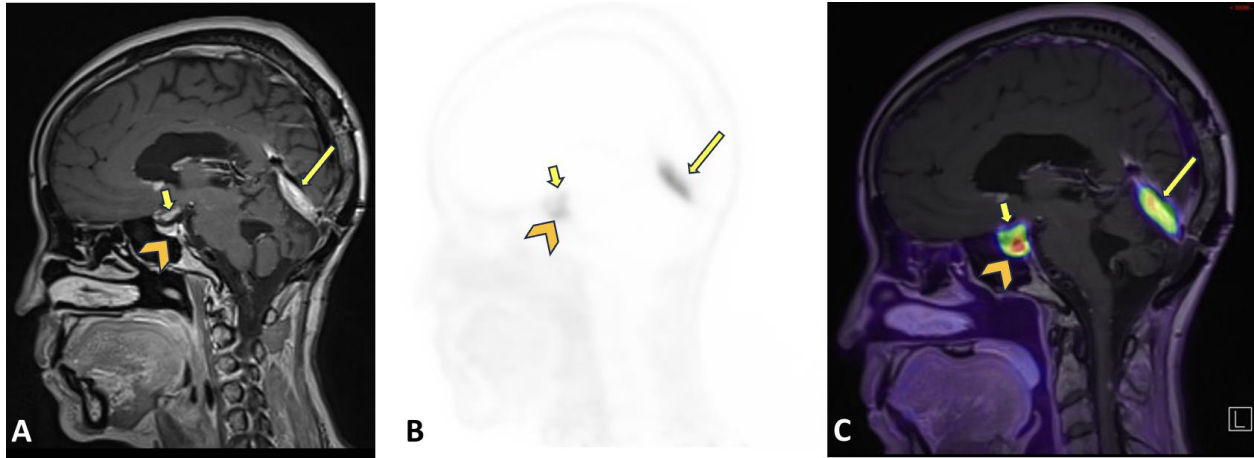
Dural based nodular enhancing mass narrowing the straight sinus (arrow) as visualized on sagittal postcontrast T1 images (A), with moderate DOTATATE avidity on PET (B) and fused PET/MRI images (C). Arrowhead representing physiologic DOTATATE avidity in the pituitary gland, better delineated against suprasellar disease (short arrow) compared to MRI alone.
